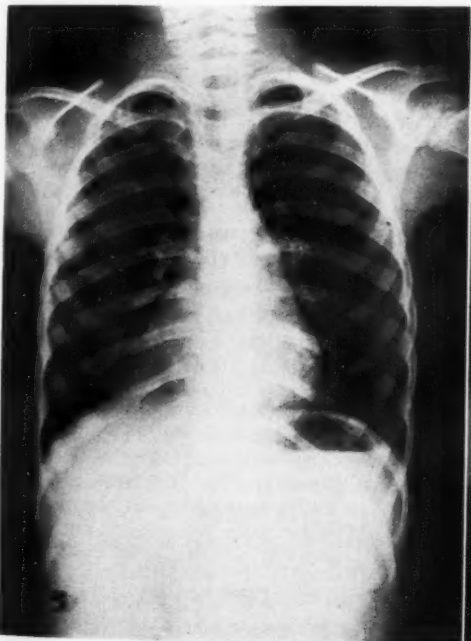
Case 19: Pericardial diverticulum. The radiographic characteristics are those of pericardial celomic cyst, but at surgery a definite connection to the pericardial cavity was demonstrated.
